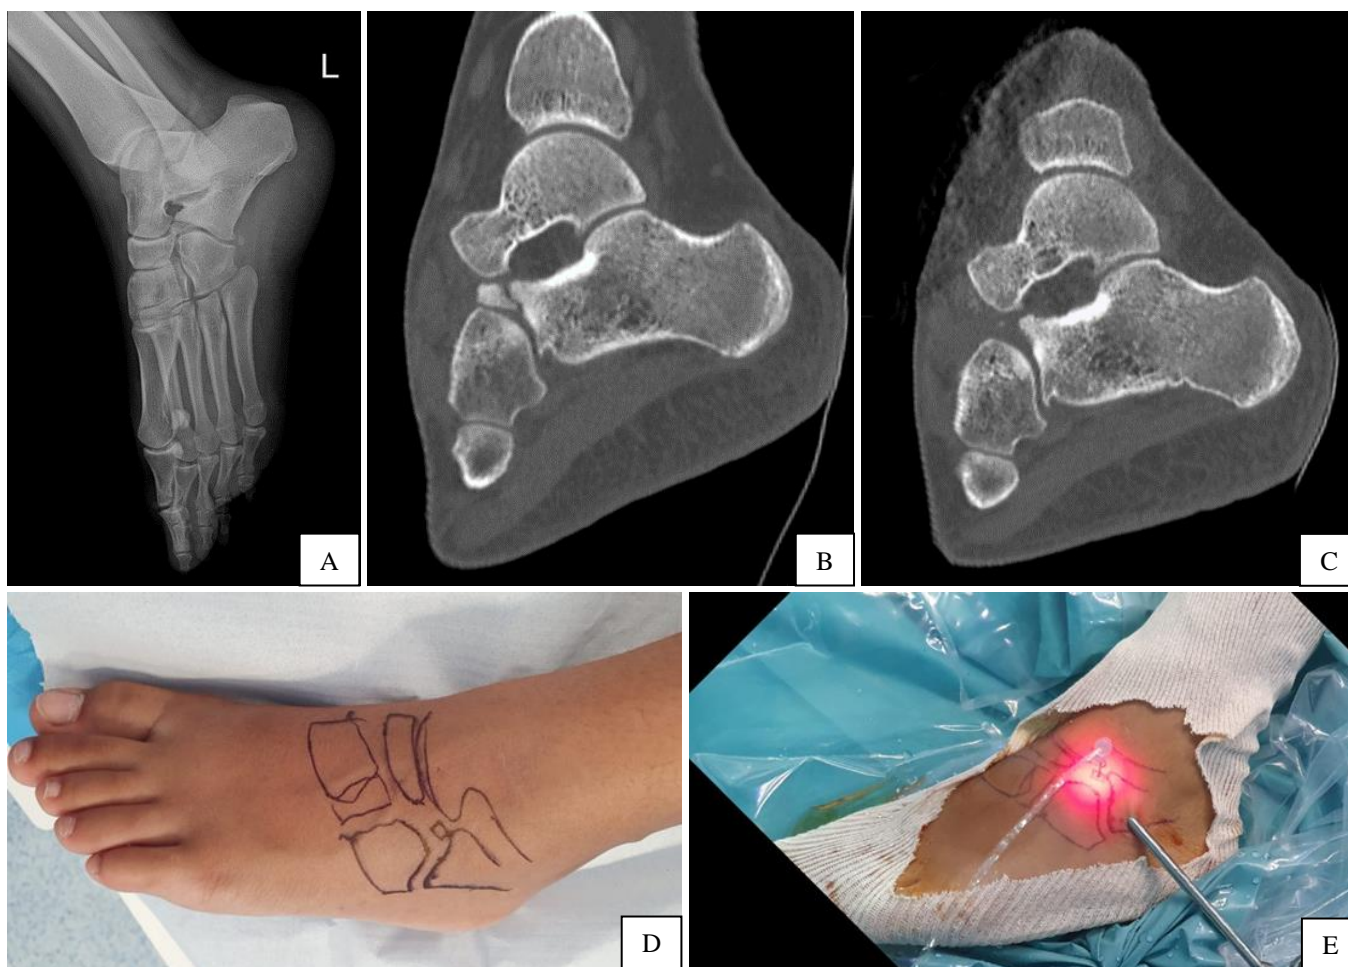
A - Anterior calcaneal process is fractured, visible at X-ray exam. B - Preoperative CT scan demonstrating the fracture of anterior calcaneal process. C - Postoperative CT scan examination, the intraarticular fragment was completely removed. D - Intraoperative landmarks identified under fluoroscopy. E - Intraoperative aspect of portal placement to remove the anterior calcaneal process.
